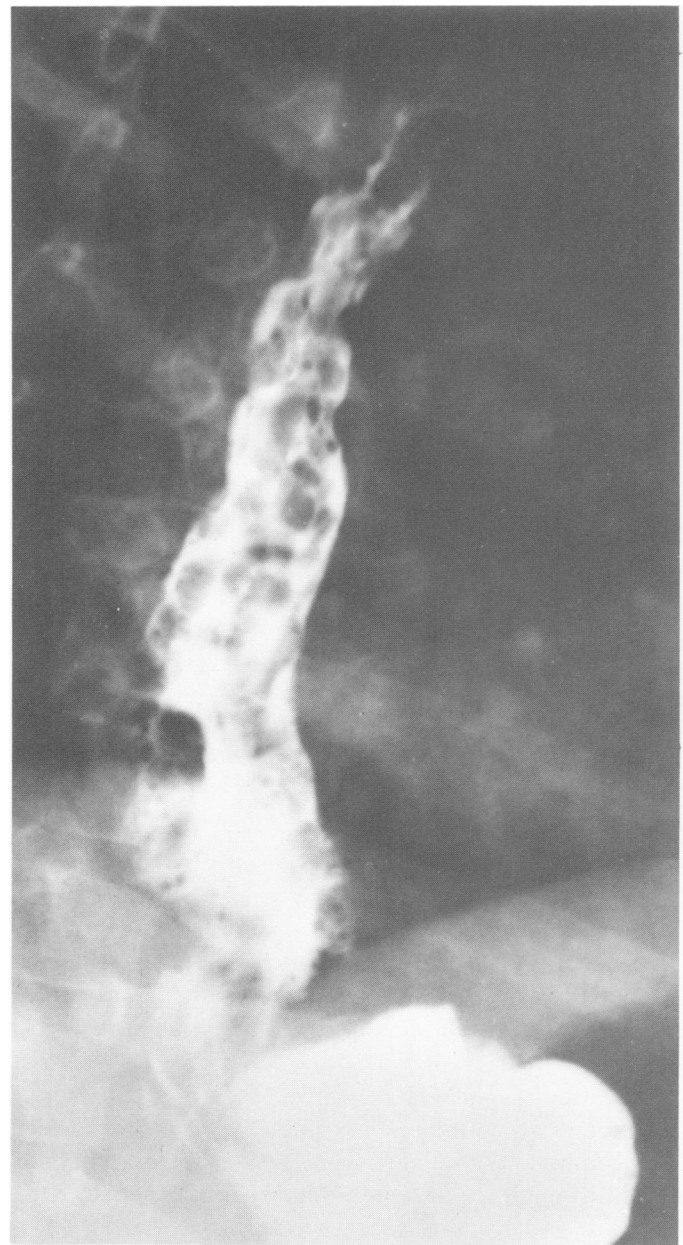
Unmistakable filling defects in the esophageal radiograph, caused by esophageal varices in a 30-month-old girl with splenic vein thrombosis resulting from umbilical vein catheterization.
